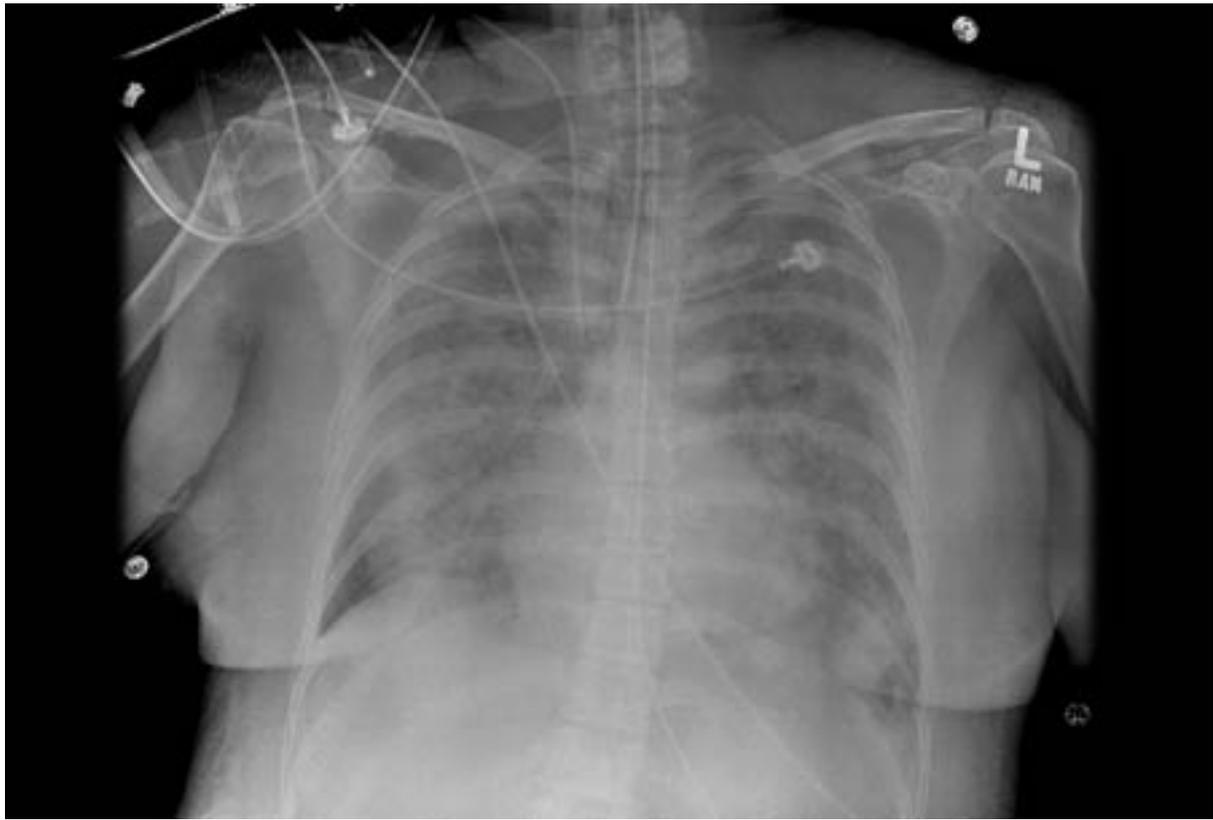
Chest x-ray image of bilateral infiltrates in a patient with ARDS
